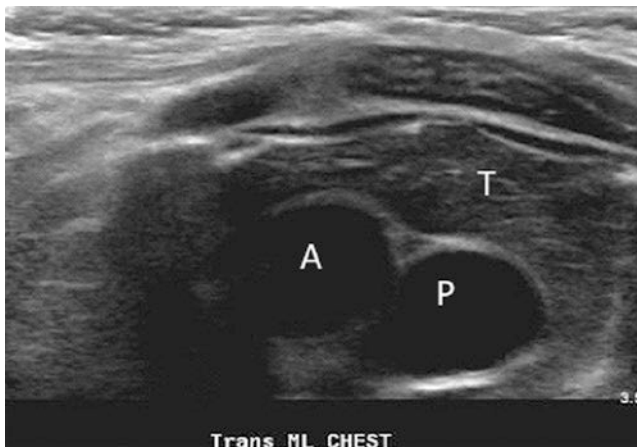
Transverse ultrasound of the mediastinum, suprasternal approach, demonstrates a normal thymus (T) and normal underlying aorta (A) and main pulmonary artery (P)
